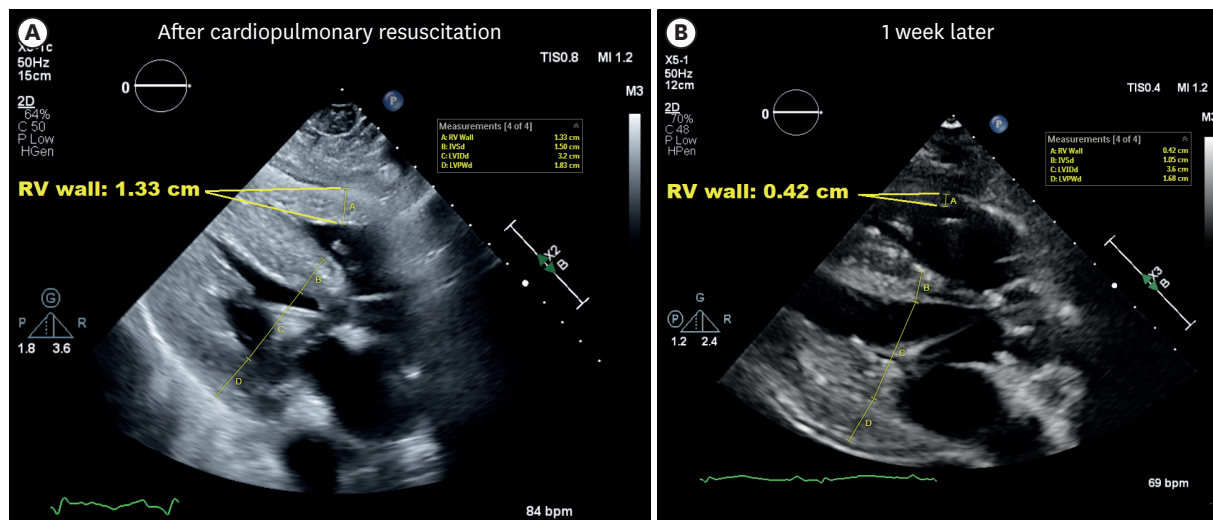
Transthoracic echocardiogram in parasternal long axis view showing right ventricular wall thickness. (A) After cardiopulmonary resuscitation and (B) 1 week later.
